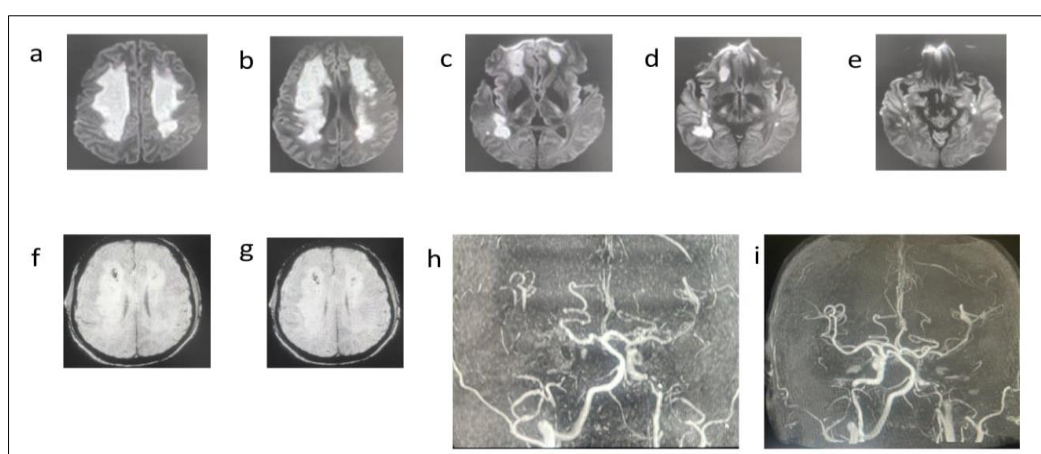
a,b,c,d,e showing DWI images: patchy infarcts in the bilateral corona radiata, centrum semiovale, and temporal lobes with mild hemorrhagic conversion notable in SWI (f and g). MRA revealing stenosis of the cervical, petrous, supraclinoid internal carotid, and proximal middle cerebral arteries bilaterally (h) and improvement of vessel stenosis post treatment (i)
